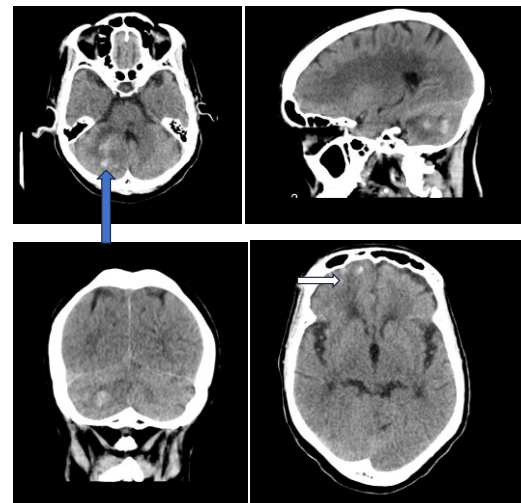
Repeat brain CT scan of the patient 9 days after the initial scan, shows resolving cerebellar hematoma (blue arrow)
